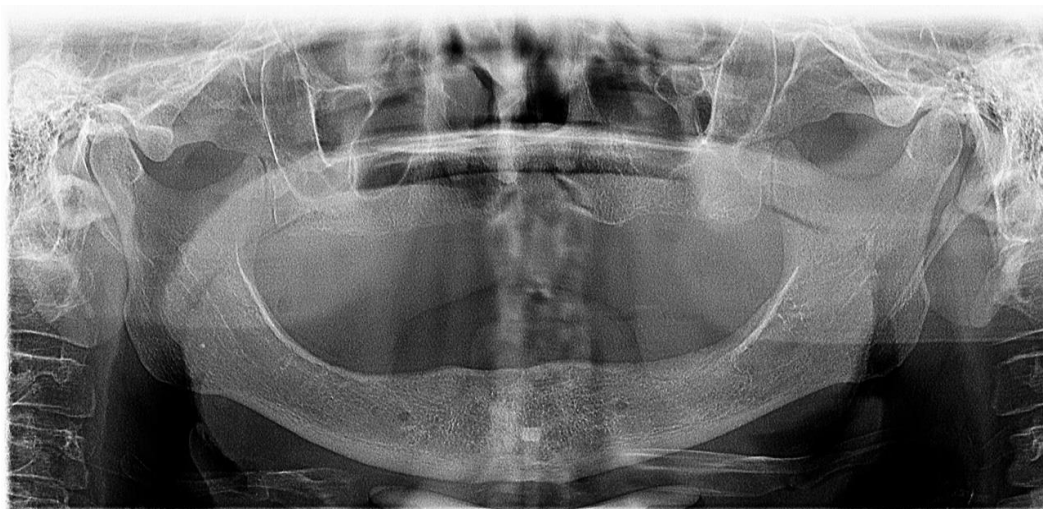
Panoramic radiograph without findings relevant to injury.
